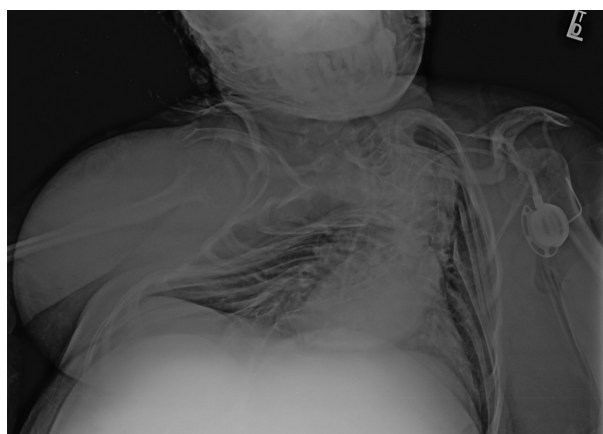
Chest radiograph. Chest radiograph showing severe scoliosis.
